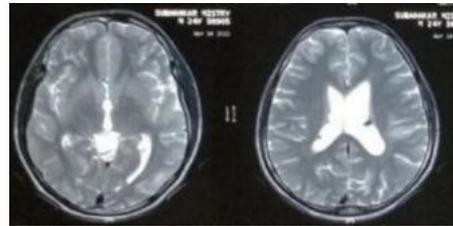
Sub-ependymal nodules in the MR imaging of brain of our patient
